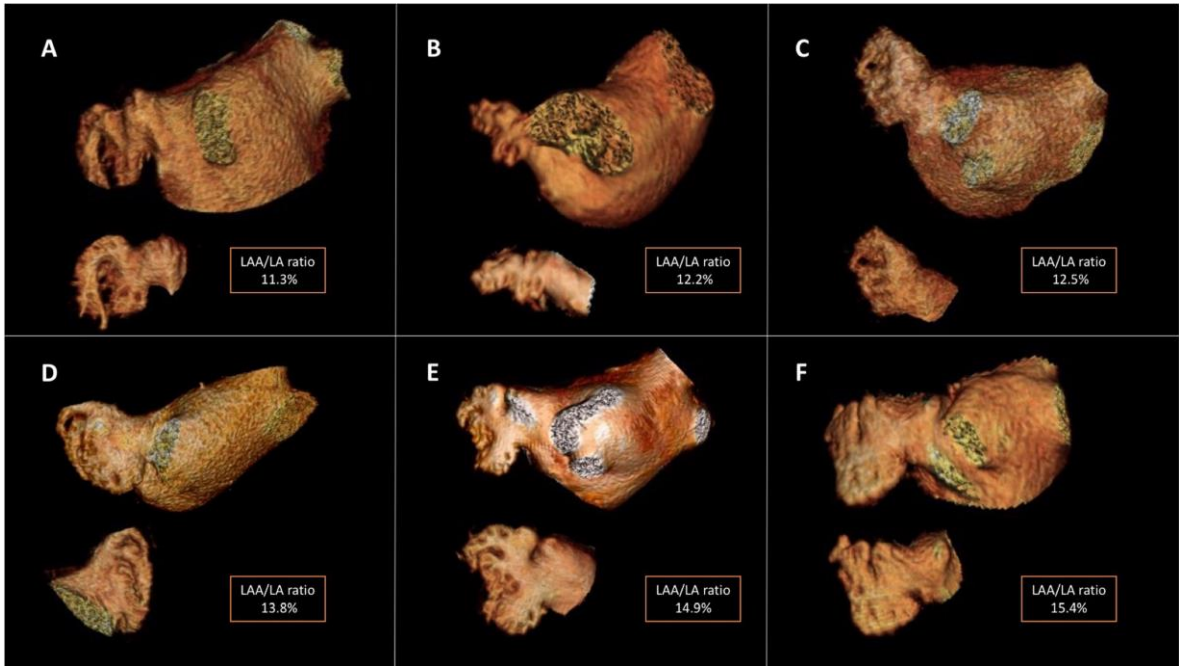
Three-dimensional computed tomography reconstruction of the left atrium and left atrial appendage.
